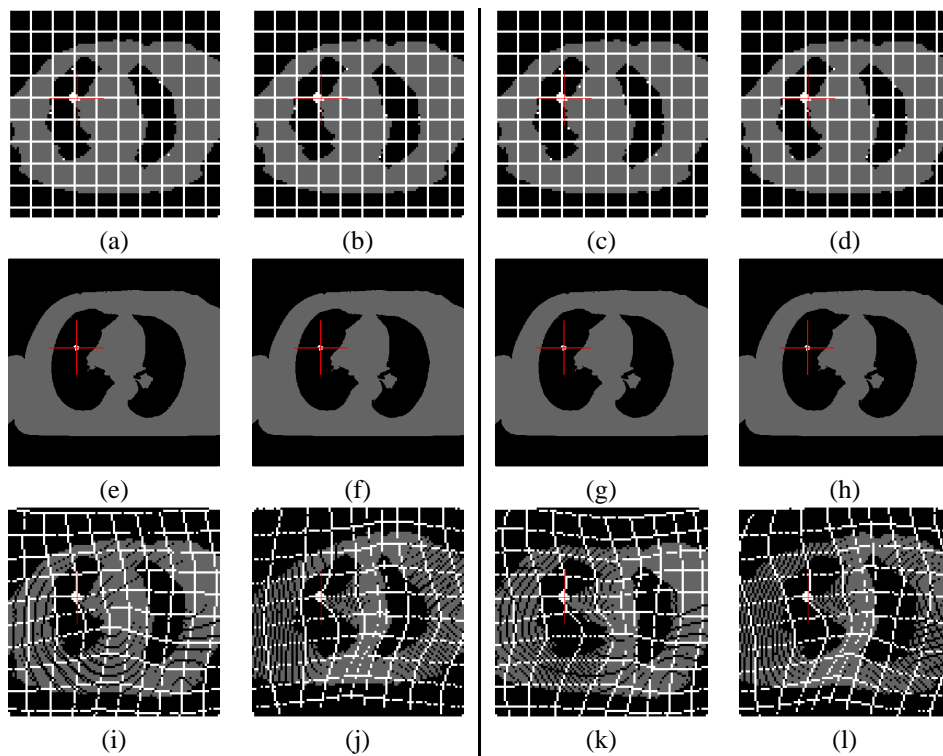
Results on simplified images. Top row: segmented PET images with a grid for visualization purpose (landmarks are also marked in white). Middle row: segmented CT images. Bottom row: results of the registration of the simplified PET and CT images using 4 landmarks (fixed on the corners of the image) and additional landmarks on the walls of the lungs. Left columns: 8 landmarks are chosen on the walls of the lungs using different distributions. Right columns: 12 landmarks are chosen on the walls of the lungs using different distributions. In all the images the cursor is centered on the tumor in the CT image.
